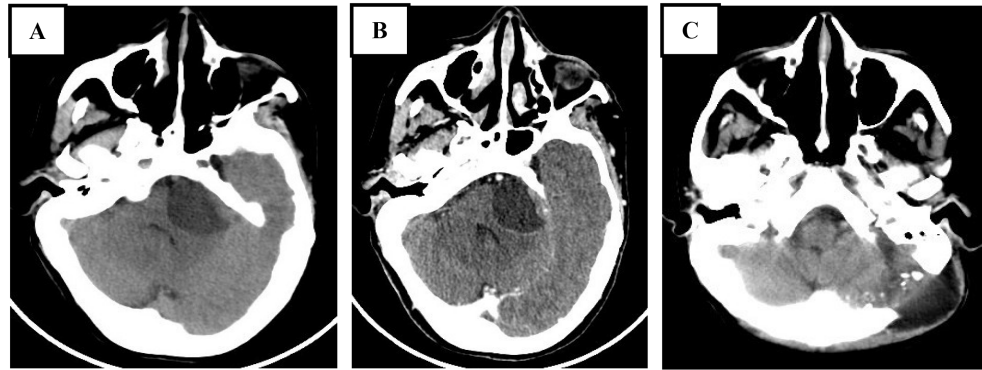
Brain CT scan in axial cut showing a cystic lesion in the left ponto-cerebellar angle with a thin wall (A), enhanced after contrast injection (B), with a fleshy component exerting a mass effect on the fourth ventricle, corresponding to a cystic acoustic schwannoma. A control brain CT scan, in an axial cut without contrast injection (C), showing a meningocele.
